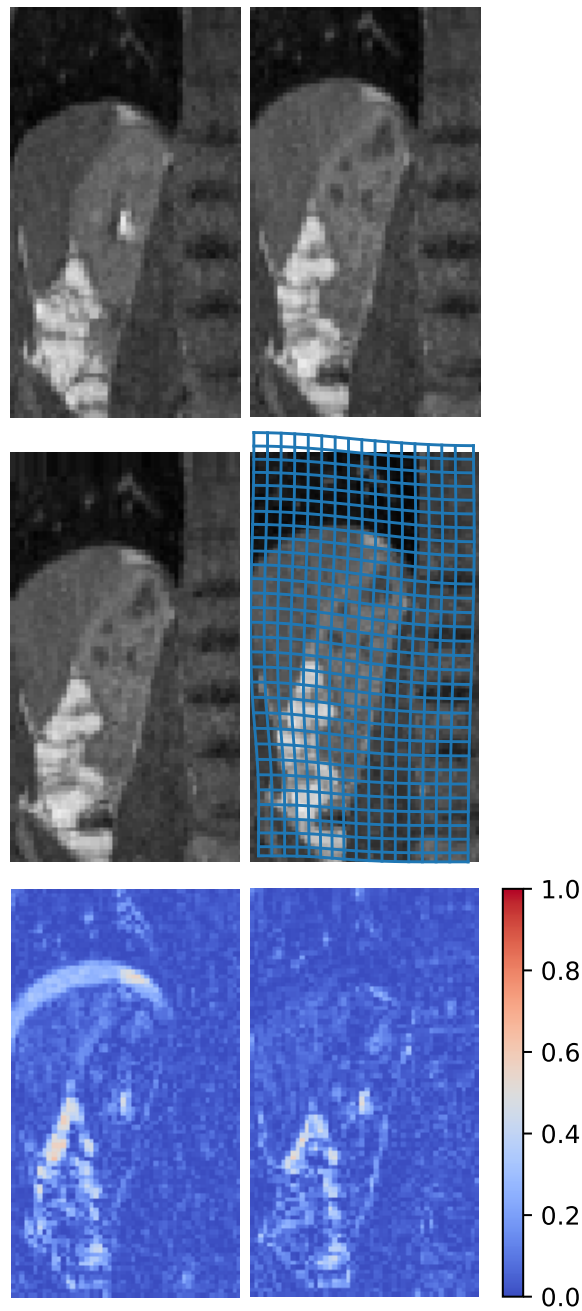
DCE-MRI data of a human kidney; data courtesy of Jarle Rørvik, Haukeland University Hospital Bergen, Norway; taken from [BWM18]. The deformation (middle row) mapping the template (top left) to the reference (top right) image, computed using our proposed model, is able to significantly reduce the misfit in the left half while fixing the spinal cord at the right edge as can be observed in the difference images from before (bottom left) and after (bottom right) registration.
